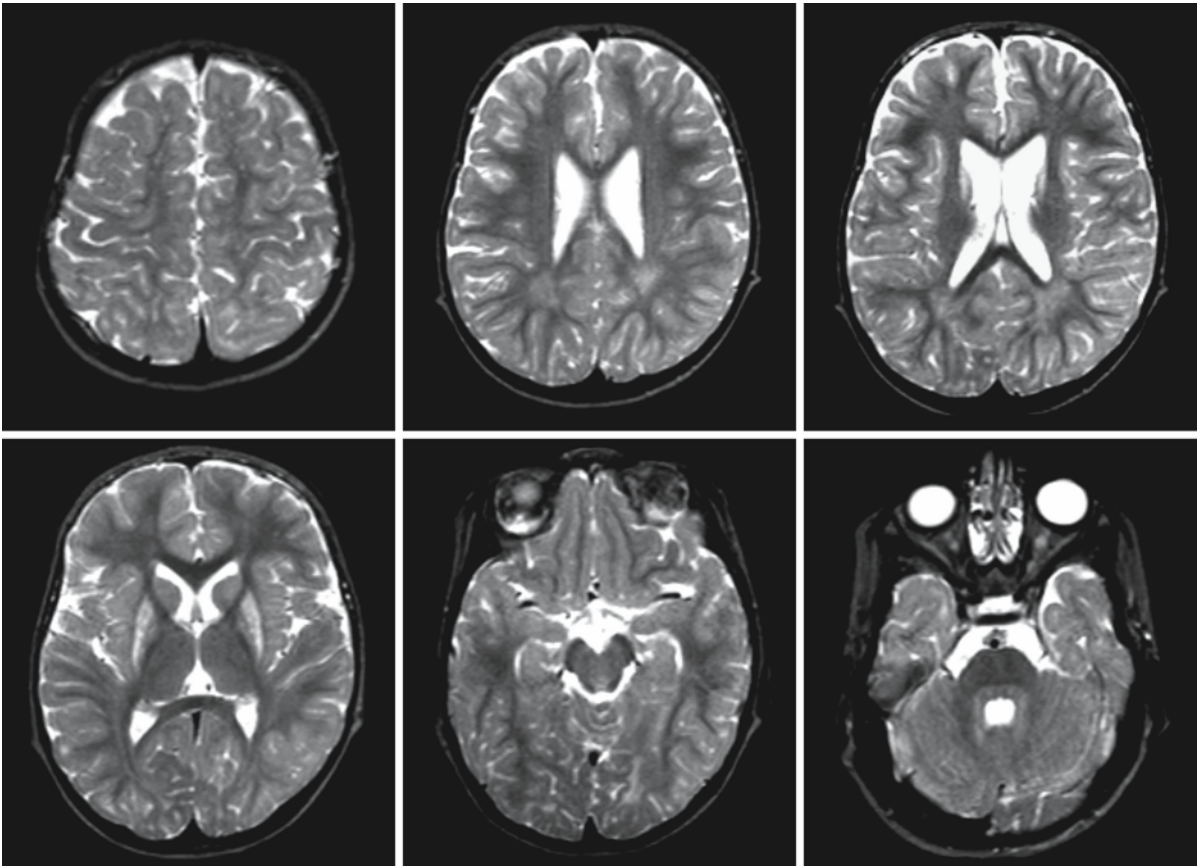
Follow-up of the boy shown in Fig. 38.3. Dietary treatment and medication were started soon after the age of 10 months and this MRI was obtained at 3 years. Myelination is now much more advanced, but still incomplete in the periventricular occipital area, the temporal lobes, and the subcortical
